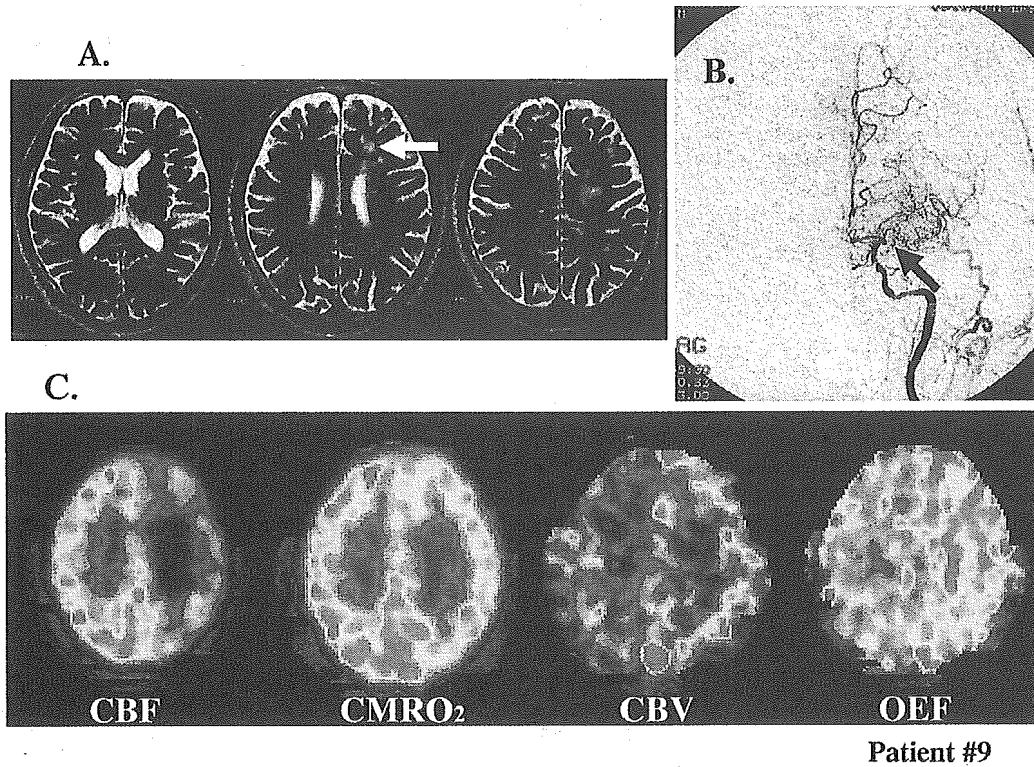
Representative MRI (A), angiography (B) and positron emission tomography (PET) images (C) in a patient with limb weakness during head-up tilt tests and misery perfusion (patient 9 in Table). (A) MRI shows ischemic lesions (white arrow) in the subcortical watershed territory of the left frontal cortex. (B) Carotid angiography shows occlusion of the left middle cerebral artery (arrow). (C) PET images demonstrate decreased cerebral blood flow (CBF), increased cerebral blood volume (CBV) and elevated oxygen extraction fraction (OEF) in the left cerebral hemisphere (OEF=58%).
